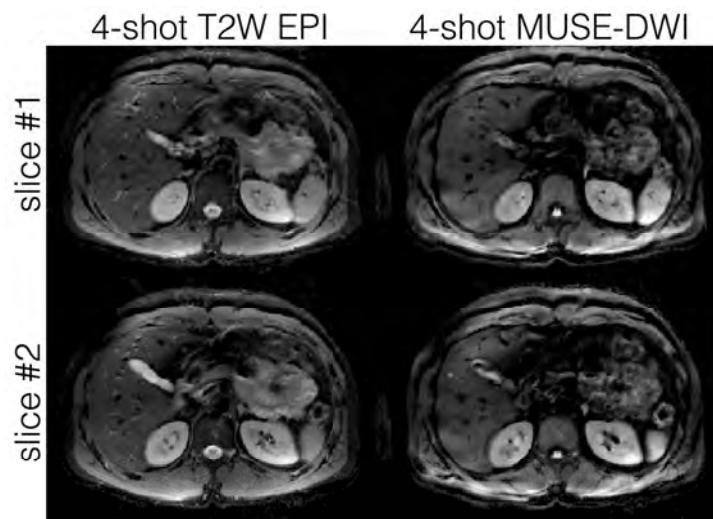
Navigator-based respiratory-gated multi-shot EPI based T2-weighted imaging and diffusion-weighted imaging (3 Tesla; b-value = 500 s/mm²)
